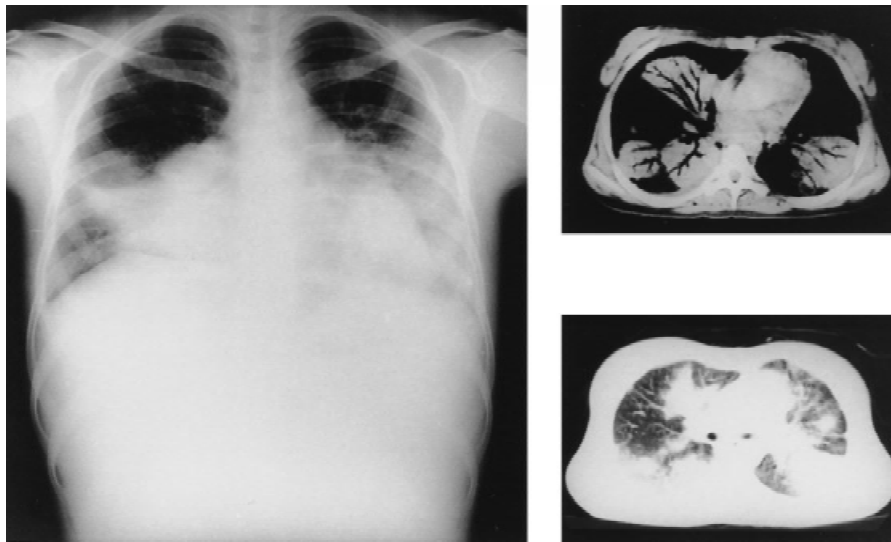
PA-radiograph and computed tomography of chest showed multiple lesions in both lung fields.
